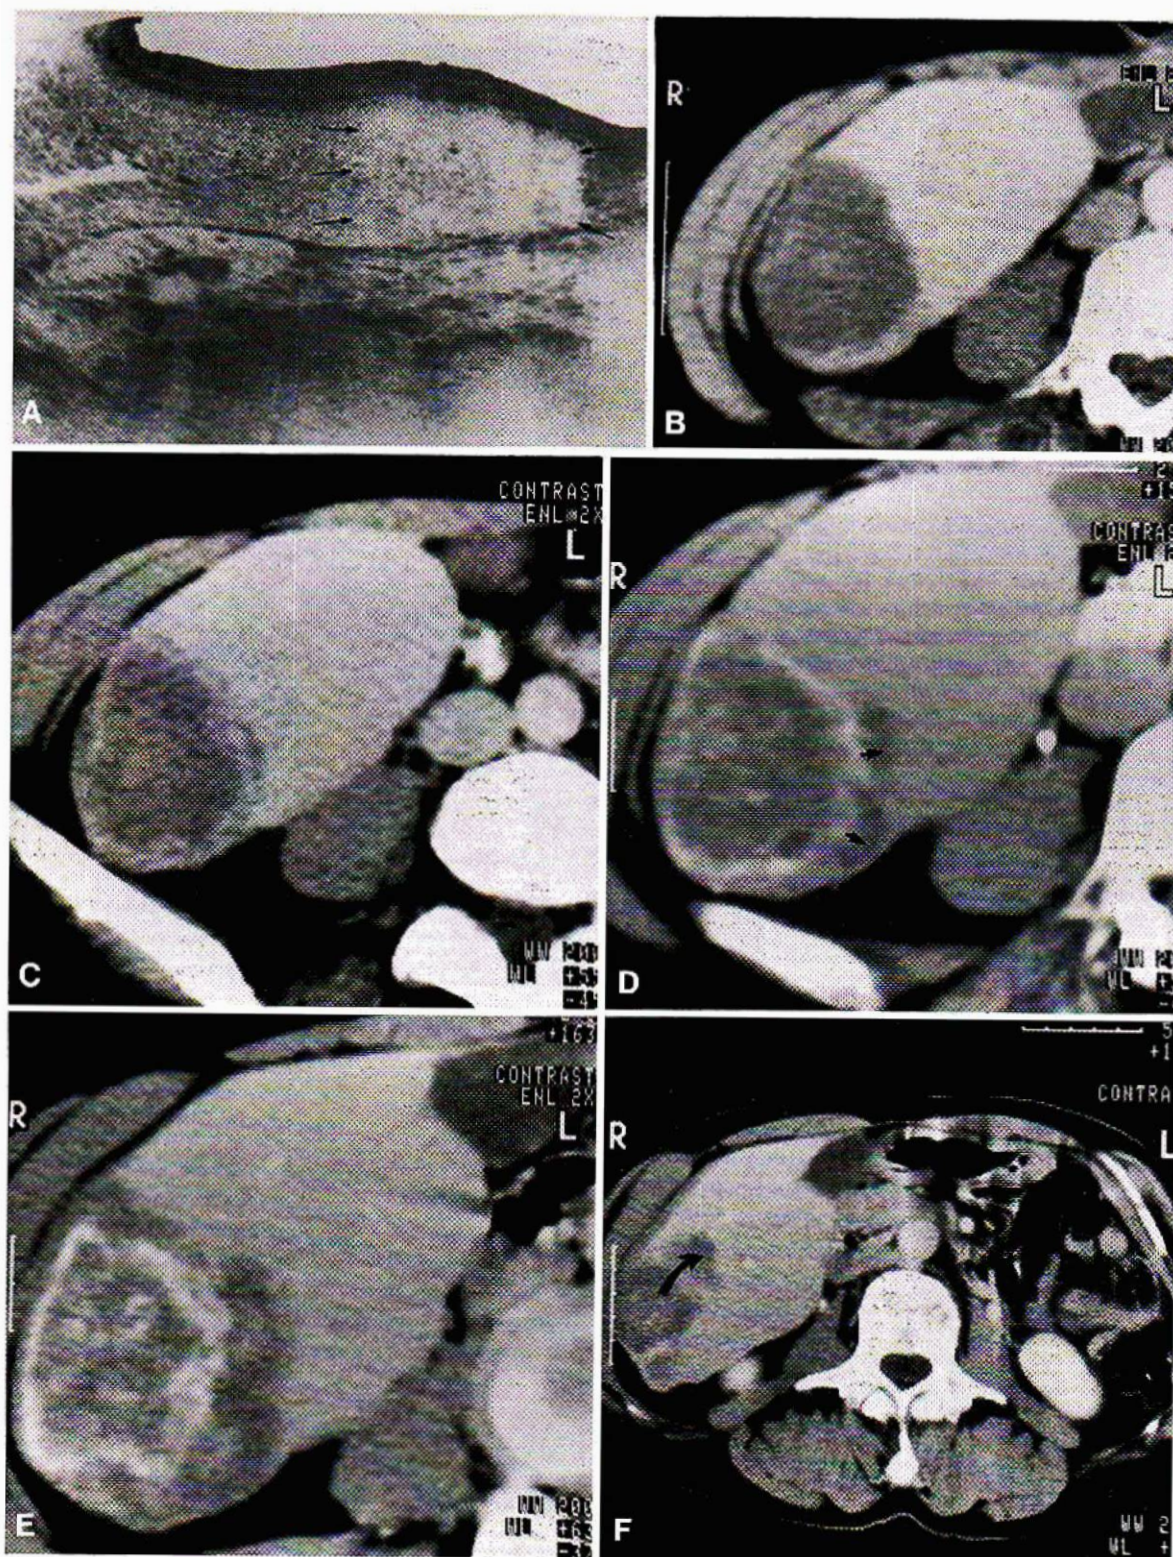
1982: A US (= longitudinal section) = initially homogeneous form (→); B post-contrast CT sections passing through the centre of the lesion.
